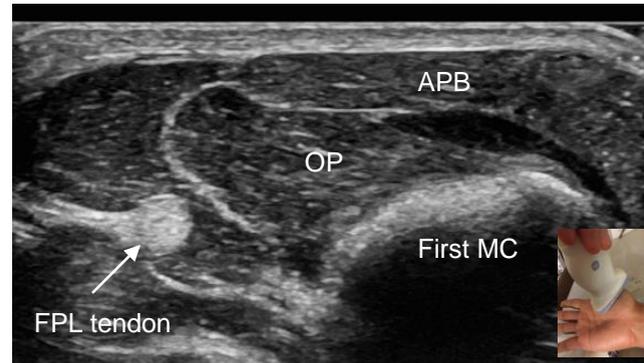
Ultrasound imaging of APB and OP muscles with probe in the short axis of the thenar eminence. The flexor pollicis longus (FPL) tendon and first MC bone are also identified in the image.
